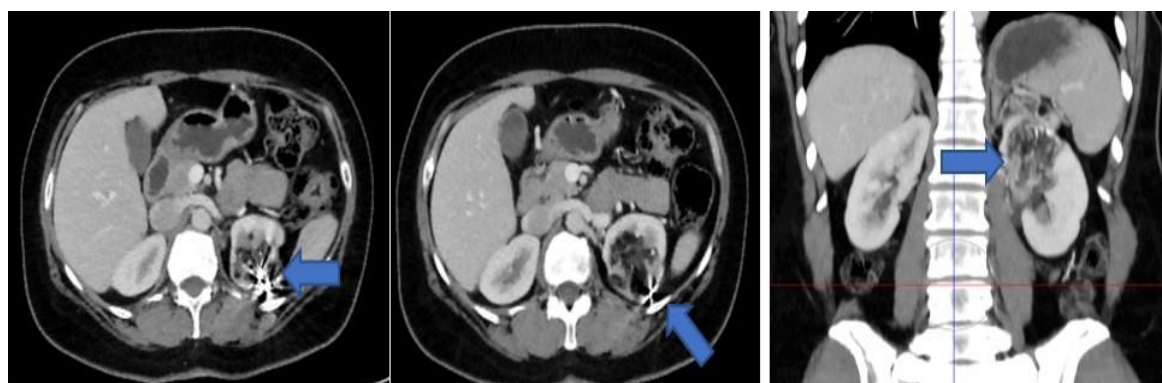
a. Axial section CT, b. Coronal section CT
